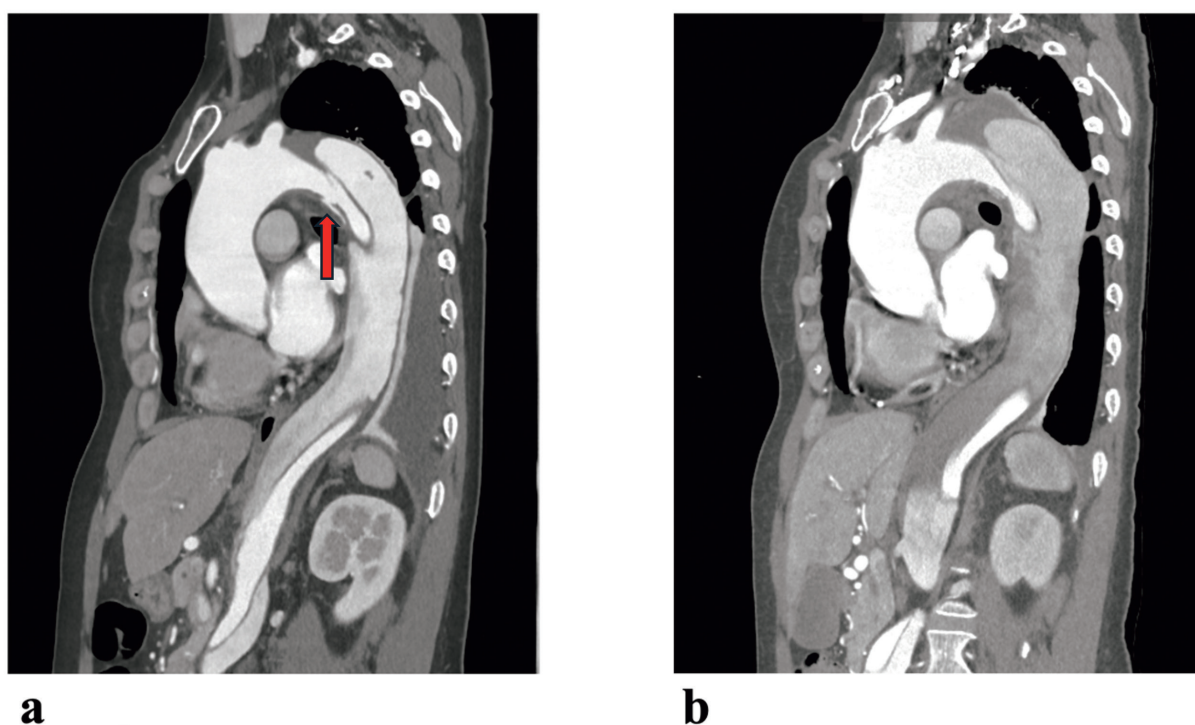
a, Contrast-enhanced computed tomography revealed aortic dissection extending from the left subclavian artery and the primary entry tear in the distal arch. The red arrow showed the primary entry tear.
